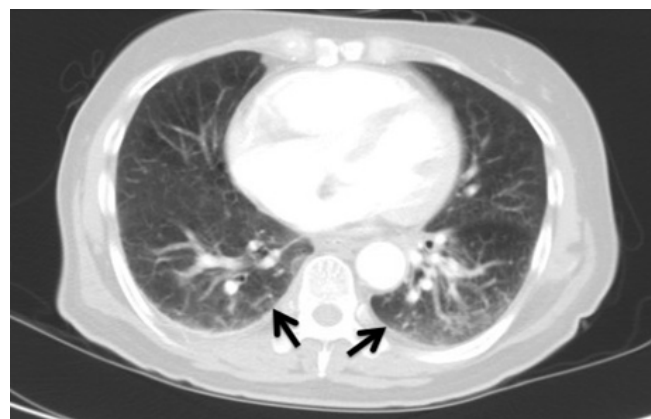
Chest CT axial series of the lower lobes with maximum intensity projection showing diffuse centrilobular nodular opacities with ground-glass attenuation associated with tree-in-bud pattern.
